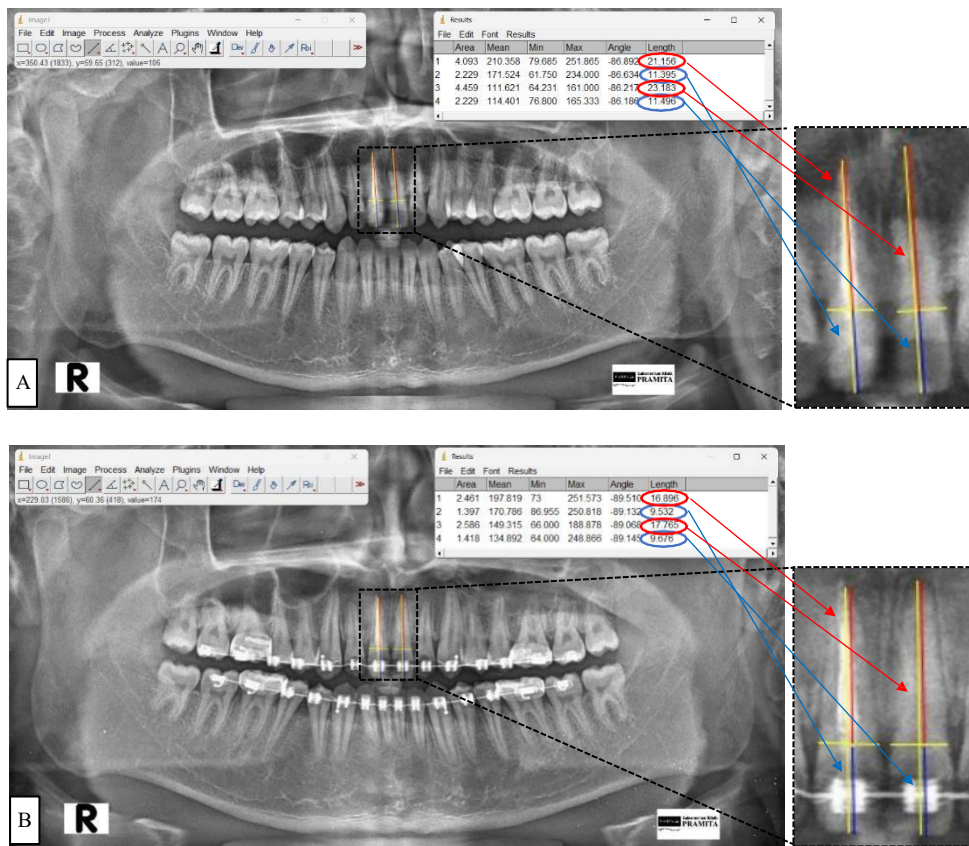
Measurement analysis on panoramic radiographs obtained before orthodontic treatment (A) and after treatment (B). Yellow lines show the cemento-enamel junction and tooth long axis, while the blue and red lines represent crown length and root length, respectively.
